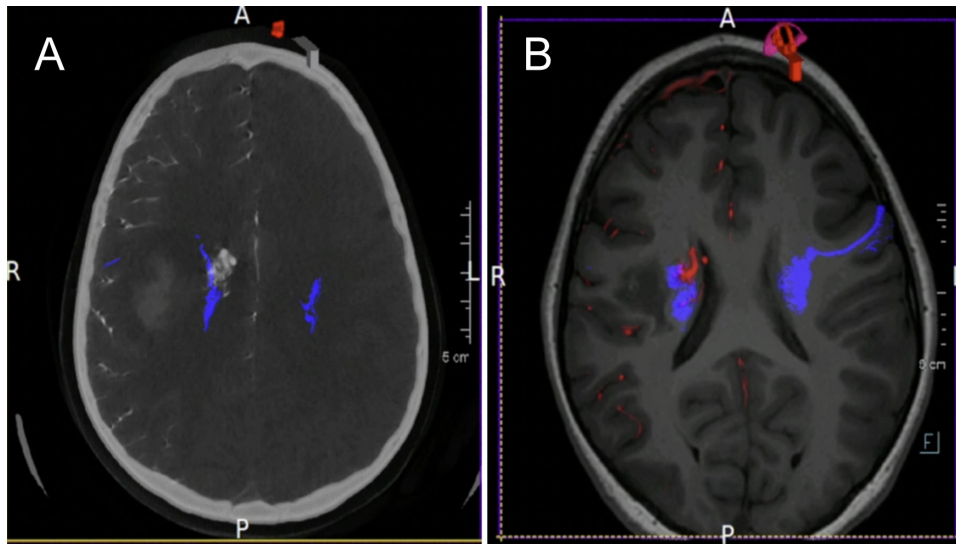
Axial slices of the patient's fused structural brain imaging, angiographic studies, and tractography at initial and delayed presentation. Comparison of the initial CT, DSA, and DTI tractography fusion (A) and follow-up MRI, DSA, and DTI tractography fusion (B) demonstrate that the CST integrity is more robust and the fibers are encasing the AVM nidus on the delayed repeat imaging.
